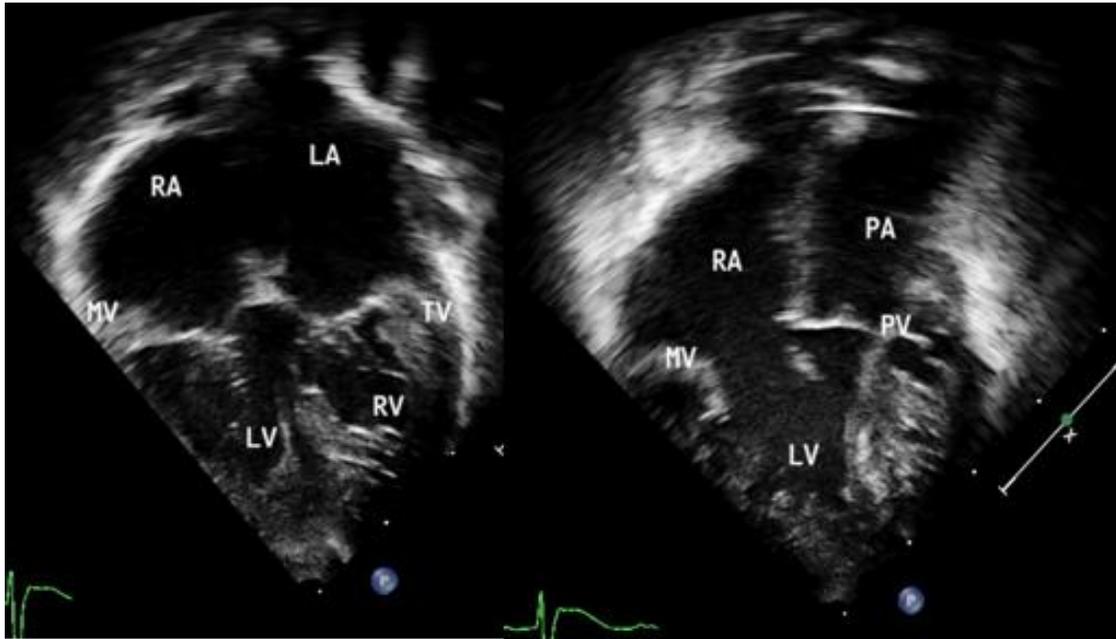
Apical four chamber views of transthoracic echo showing congenitally corrected transposition of the great arteries, atrioventricular discordance and ventriculoarterial discordance (RA to LV to PA) (LA to RV to AO) (LA: left atrium, RA: right atrium, PA: pulmonary artery, LV: left ventricle , MV: mitral valve, AO: aorta, RV: right ventricle, PV: pulmonary valve)
